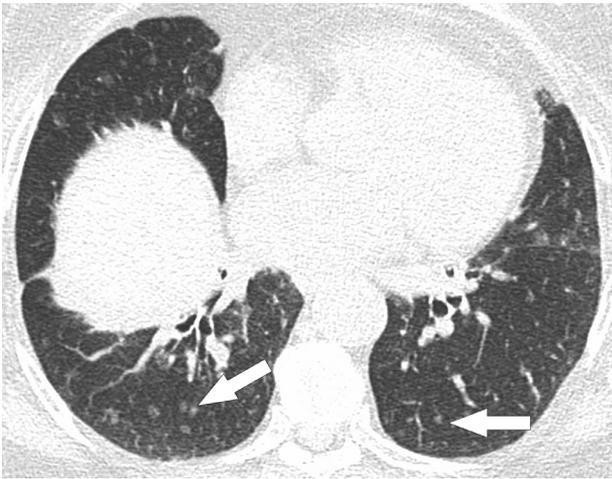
A 43-year-old female with RA and follicular bronchiolitis. HRCT images show poorly defined centrilobular ground-glass attenuation nodules (arrows). Courtesy of Arlene Sirajuddin, M.D. (Bethesda, MD). RA, rheumatoid arthritis.
